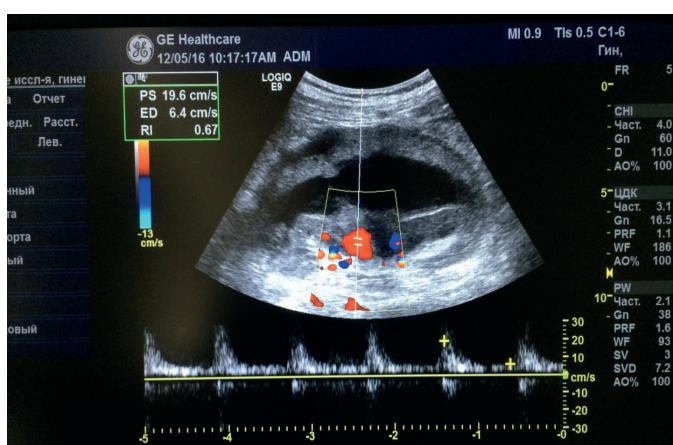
US of the left kidney. Colored and pulse-wave Doppler. Anechoic component - subcapsular hematoma. Red section - projection of the renal artery aneurysm.
